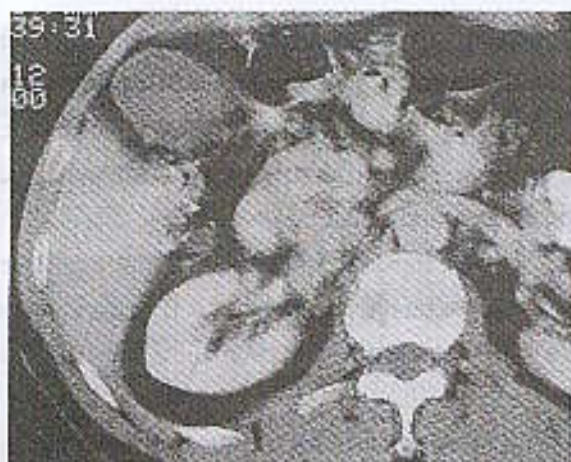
The computed tomography (CT) demonstrated a heterogeneous mass, 3.5x3.5x4.0 cm, at the pancreatic head and uncinate process obstructing the biliary tract, possibly invading the duodenal loop, with suggestive evidence of superior mesenteric vein and inferior vena cava invasion. No isolated peripancreatic, periportal or paraaortic lymphadenopathy was demonstrated.
